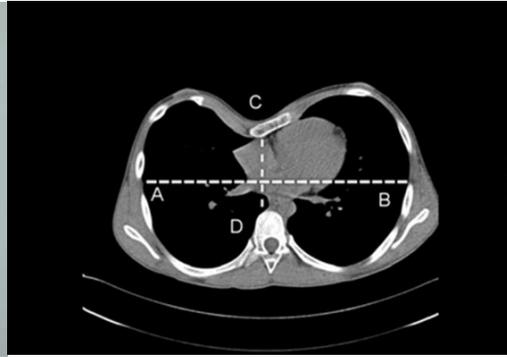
CT, Haller index calculation
